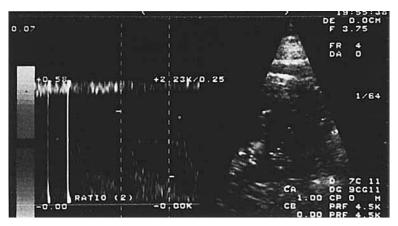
Color flow imaging and Doppler spectrum obtained from the interlobar and arcuate arteries were normal.
